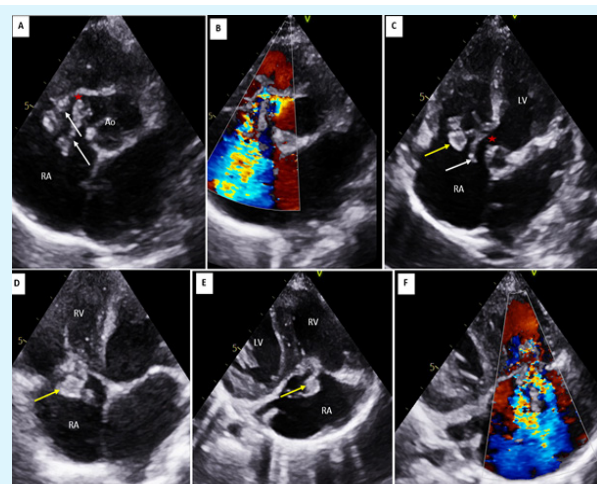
Echocardiographic findings of a Gerbode defect complicated by infective endocarditis.
